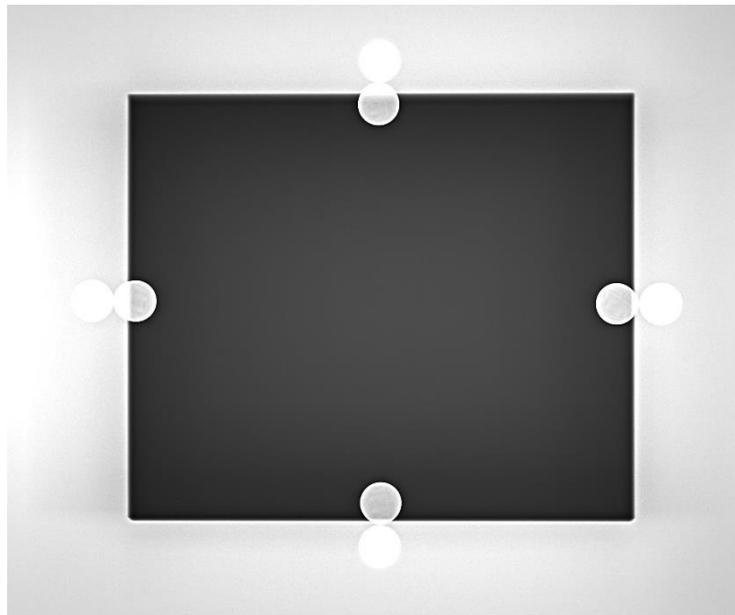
Light beam test from one of the X-Ray unit
